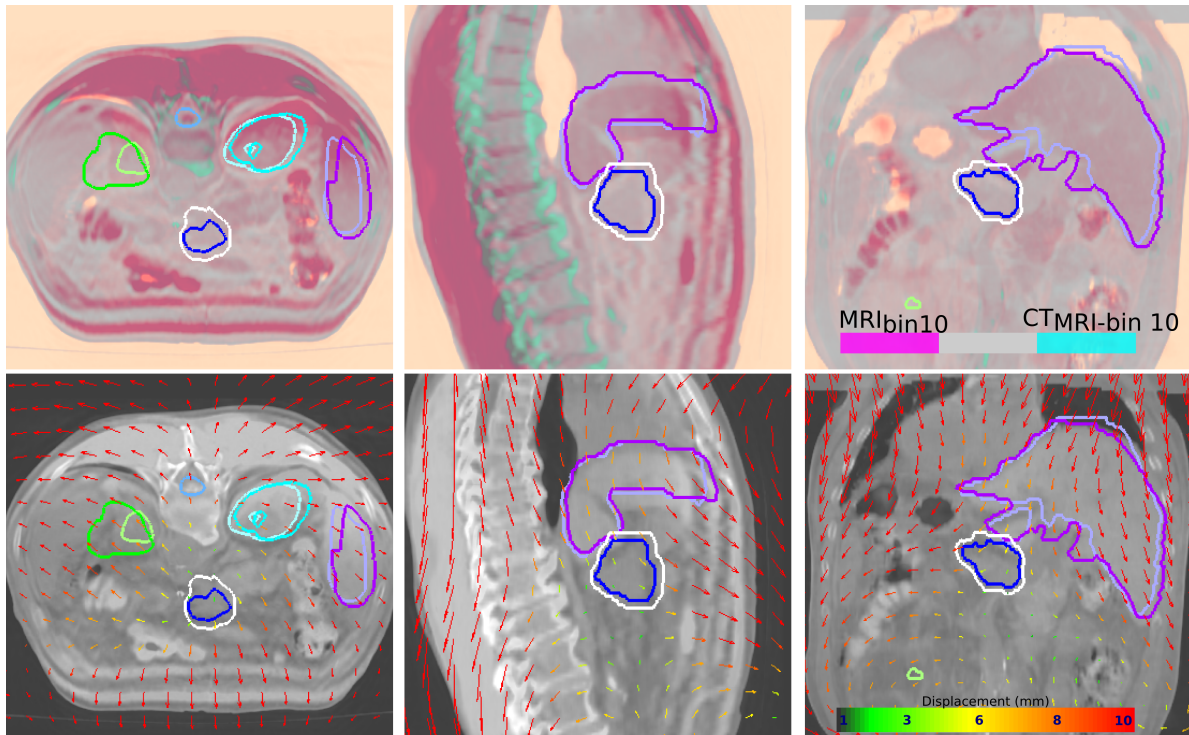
Visual inspection of the DIR MRI-CT for the example of the patient H13, 1st session for the bin 10. Upper images show the *false colour* comparison between the original MRI-bin10 and the transformed planning-CT, i.e. CT_{MRI-10} . From this overlay some mismatch between the two images (i.e. blue or pink colour) is detected, which is however small in the central body region. Structures of the original planning-CT and CT_{MRI-10} are also superimposed. Kidneys and liver are represented by the light colours for the original VOI and by the dark colours for the propagated to the bin 10. ITV_{bin10} is represented in white and CTV_{bin10} in dark blue.
